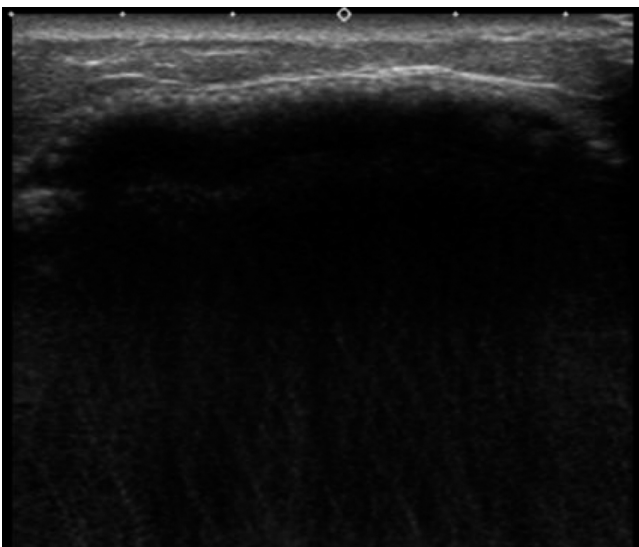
Ultrasound shows a linear hyperechoic image with intense posterior acoustic shadowing at the left breast upper quadrants, which impair the evaluation of the underlying breast parenchyma.
